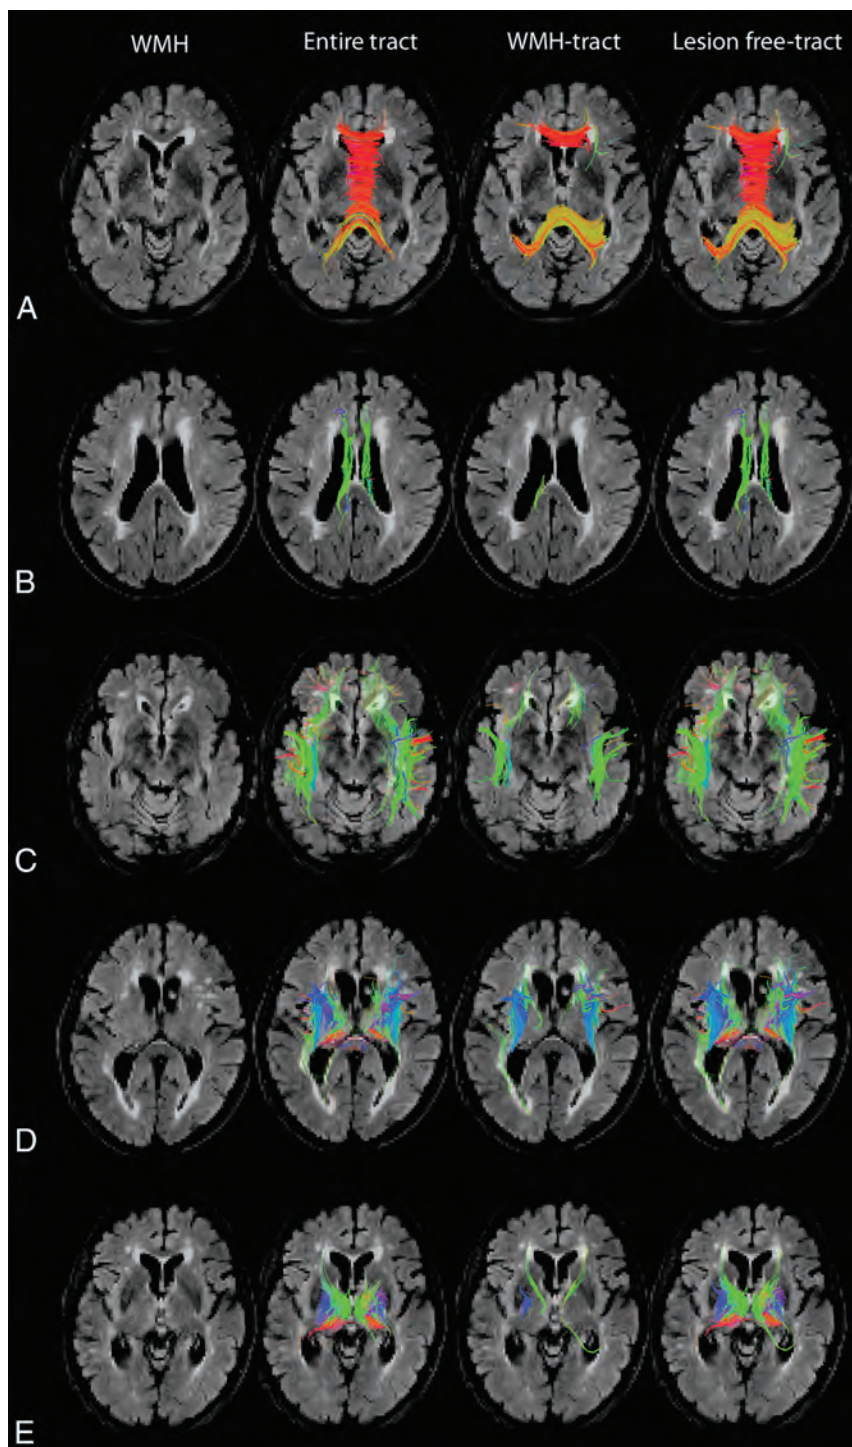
Tract segmentation, WMH tracts, and lesion-free tracts. Axial T2 FLAIR demonstrates white matter hyperintensities, tractography representation of the entire tracts, WMH tracts, and lesion-free tracts in the corpus callosum (A), cingulum (B), association fibers (C), corticospinal/bulbar tract (D), and thalamic tracts (E).
